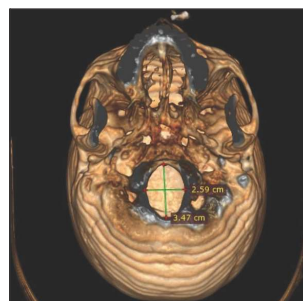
CT Scan image showing measurements of foramen magnum length (FML) and breadth (FMW).
